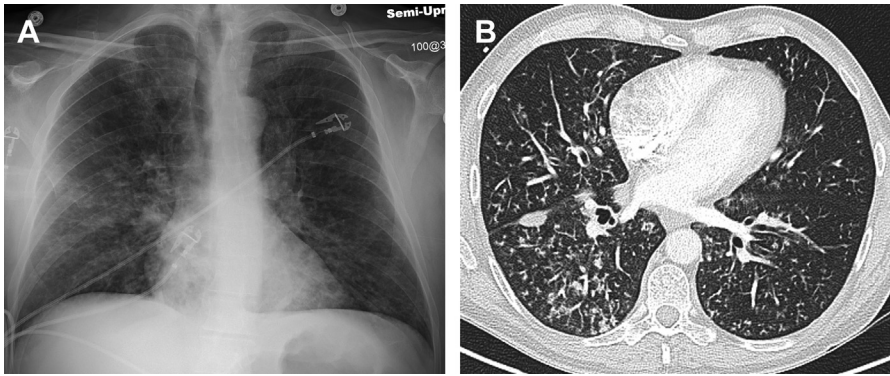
Influenza B in a 60-year-old man. (A) Frontal chest radiograph demonstrates perihilar-predominant bilateral reticulonodular opacities with bronchial wall thickening. (B) Axial chest CT shows extensive bilateral centrilobular nodules, including tree-in-bud distribution, and bronchial wall thickening indicating bronchiolitis and bronchitis, airway-centric disease. Incidental focal fluid within the right major fissure.
